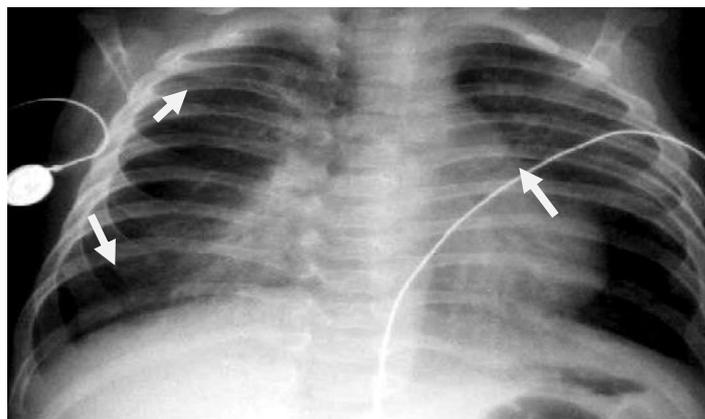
Plain chest x-ray (antero-posterior view) showing pneumonic infiltration (consolidation) at upper and lower right lung lobes and at the upper left lung lobe.
